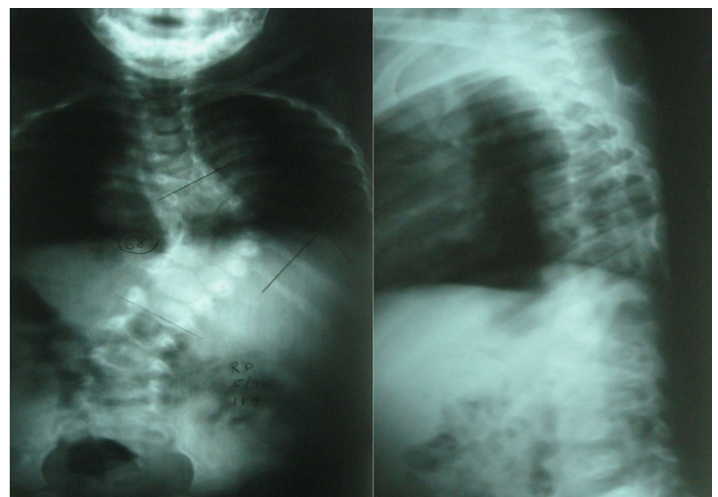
Case 1 - AP and lateral X-Ray views of case 1 patient's spine at 2 years old with a Cobb angle of 68°.
